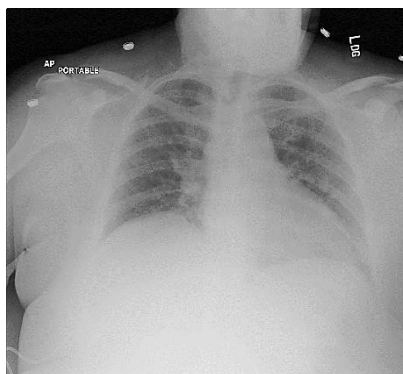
Hernia Chest X-ray
